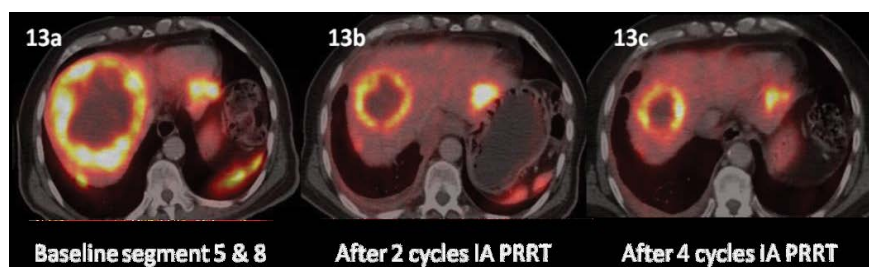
Patient 3. Largest lesion in the right lobe (segment V/ VIII) measured 10.9 x 10.3 cm with SUVmax: 73, which decreased to 4.7 x 5.5 with SUVmax: 31 after 2nd cycle and further to 4.0 x 4.2 cm with SUVmax: 25 after the 4th cycle with corresponding decrease in SUVmax suggestive of partial metabolic response.
